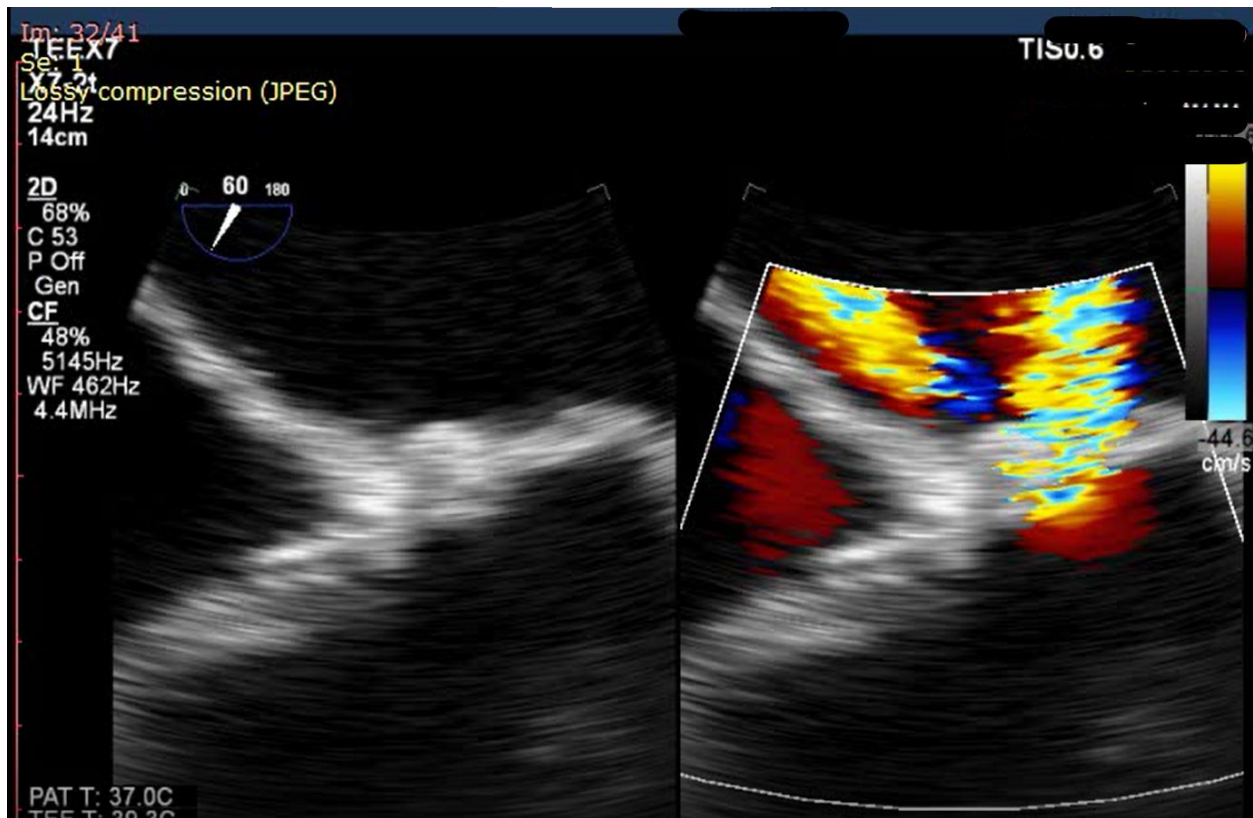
A pair of images taken from an animated set of transesophageal ultrasound images. The left image shows the barrier between the atrium and ventricle. The right shows the jetting flow of blood backward from the left ventricle to the left atrium. (Photo has been modified to protect patient confidentiality.) [13]
